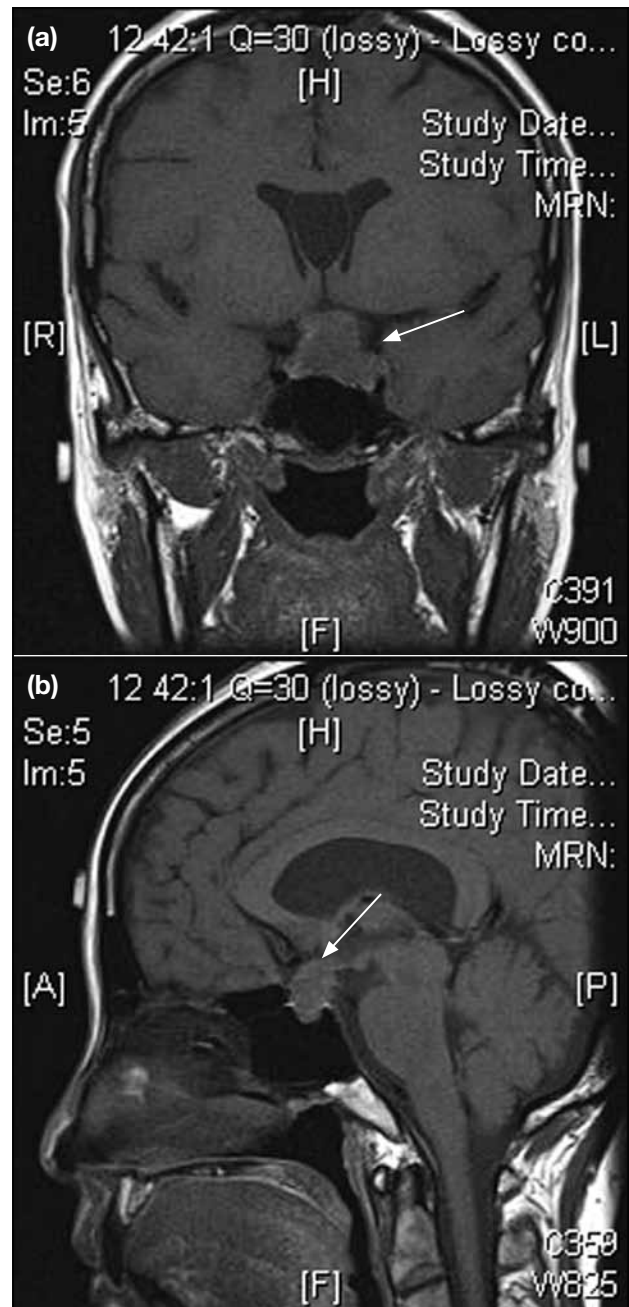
Isointense-to-hypointense lesion at the sellar region extending to the suprasellar region and compressing the optic chiasma (arrows) on T1-weighted magnetic resonance imaging: (a) coronal view and (b) sagittal view.
